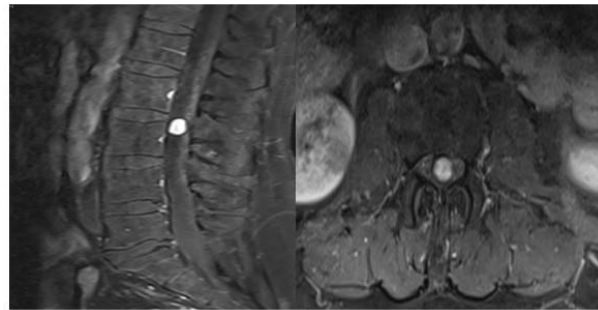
On magnetic resonance imaging, a hyperintense mass lesion with contrast enhancement in the spinal canal at the L3 vertebra level, on T1 sagittal and axial sections.
